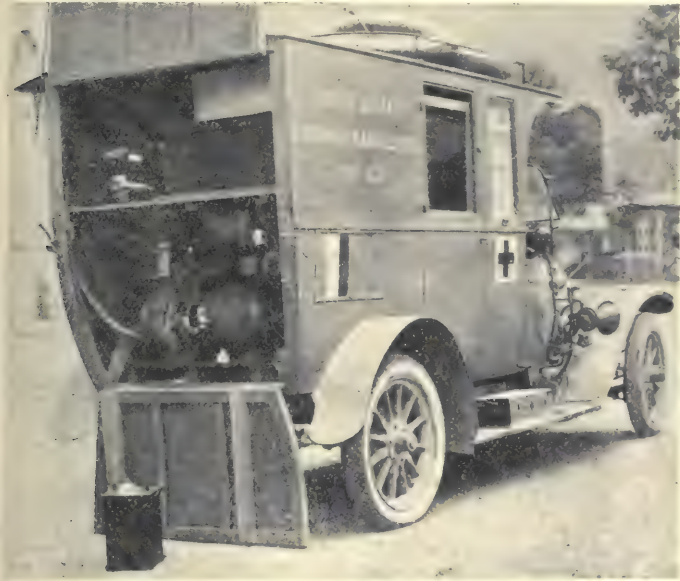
X-ray car constructed by the firm Gallot, a type used by the armies and at the bases.
